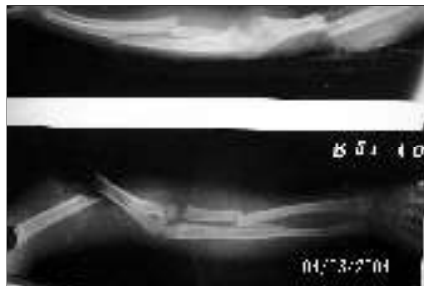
Pre-op X-ray showing ipsilateral compund fracture humeus and radius ulna
